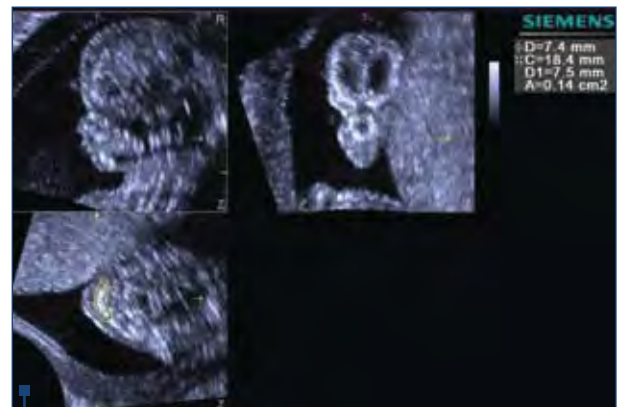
Maxillary alveolar ridge in yellow in a 3D ultrasound
